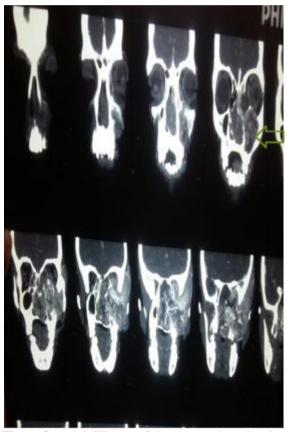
Axial CT scan of the same patient showing extensive nature of JA. The lesion was measured 70x48x52mm in size extending into pterygopalatine and infratemporal fossa and also invading infraorbital region.
